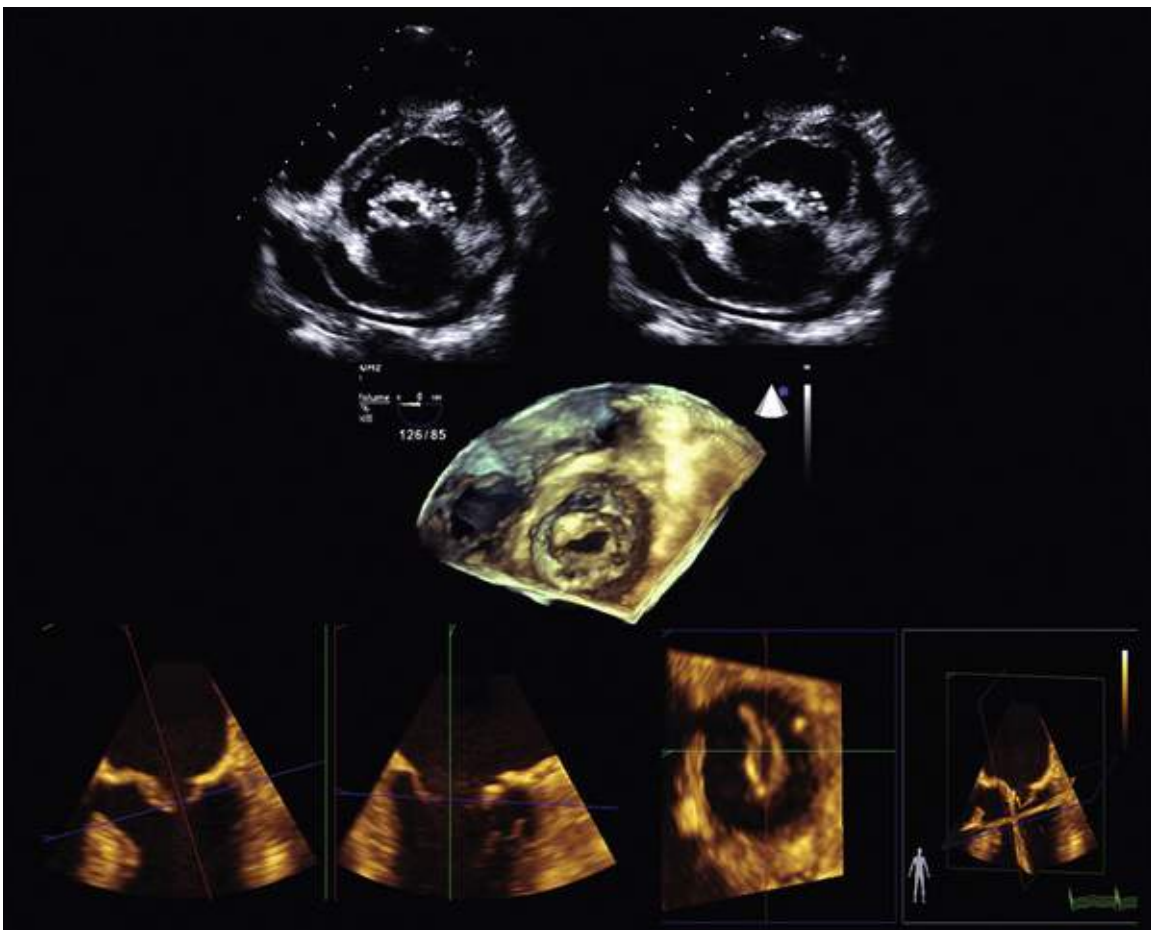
Approaches to planimetry of the mitral valve area (MVA) in rheumatic mitral stenosis. Top panel, Planimetry of 2D parasternal short-axis images. Middle panel, 3D TEE view of the stenotic orifice from the perspective of the left ventricle, which can be directly planimeted. Lower panel, Multiplanar reconstruction of 3D TEE volumes can ensure that a short-axis view precisely at the level of the limiting orifice is selected for planimetry.
